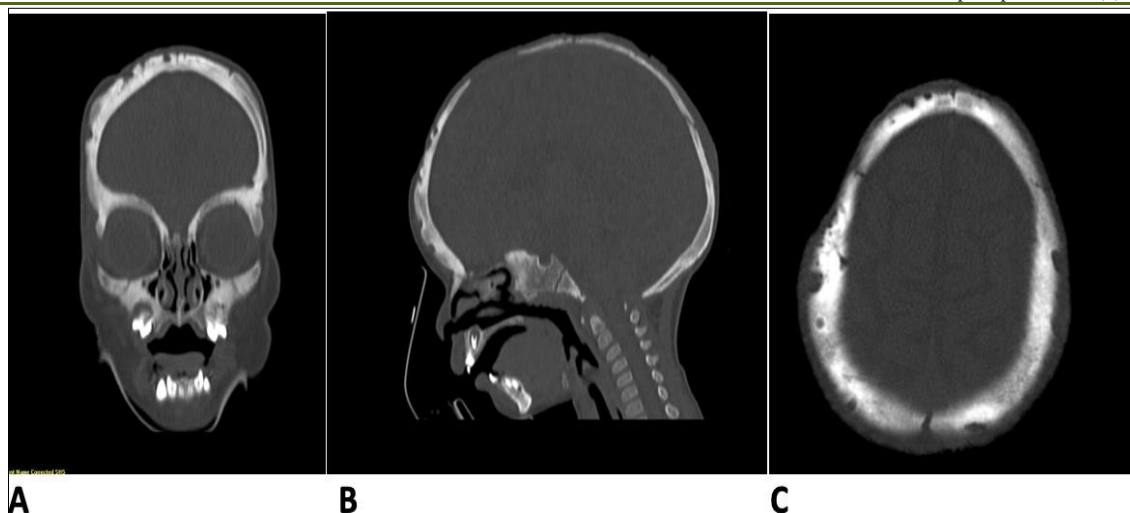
(A, B, C,): Spontaneous contrast brain CT, in coronal, sagittal and axial slices, showing: multiple mixed osteocondensing and osteolytic bone lesions with cortical rupture, some of which were visible throughout the skull, but more marked at the level of the arch with the scalp collection already described on ultrasound, with no detectable intracerebral lesions.
